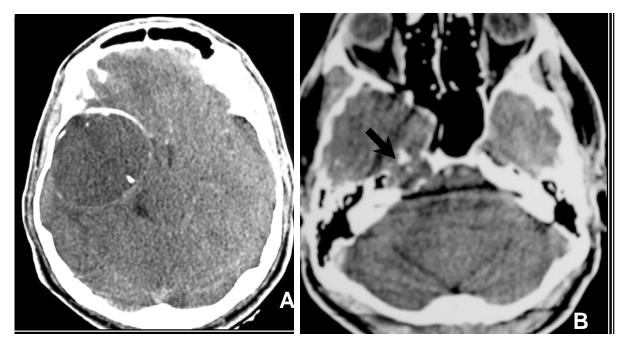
A,B Axial contrast-enhanced CT shows hypodens mass extending to the right temporal lobe. Curvilinear calcified wall, punctate calcifications in the lesion with moderate mass effect are seen (A). Petrous bone destruction is seen on CT scan at the level of skull base (arrow) (B).
